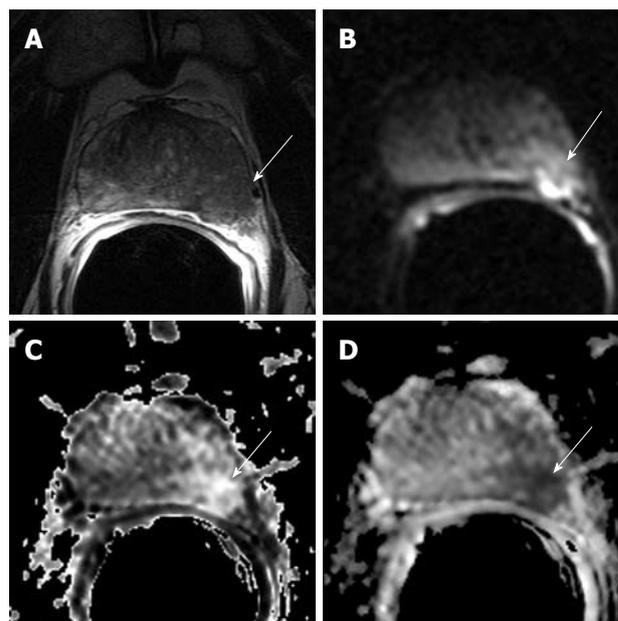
MR images of established ECE of prostate cancer into the periprostatic fat in a 59-year-old man with PSA level of 21.7 ng/mL and Gleason grade 4 + 4 and PT3a. Transverse 3 mm-thick MR (5800/108) image (A) and transverse diffusion image (4000/85, b1000) (B), exponential ADC (C) and ADC (D) of the prostate mid-gland reveal an infiltrative peripheral zone tumor (arrows) that extends into the left periprostatic fat.
